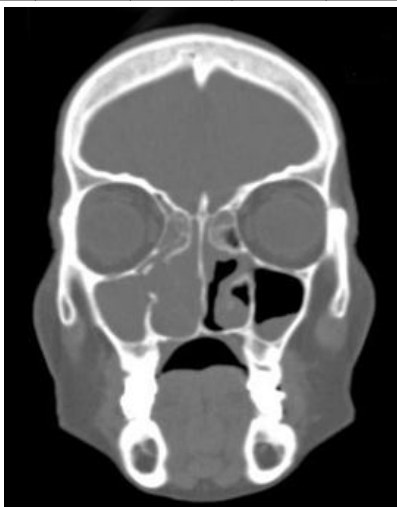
Figure no:5 Coronal and axial CT Scan images showing pansinusitis with right sided sinonasal polyposis
